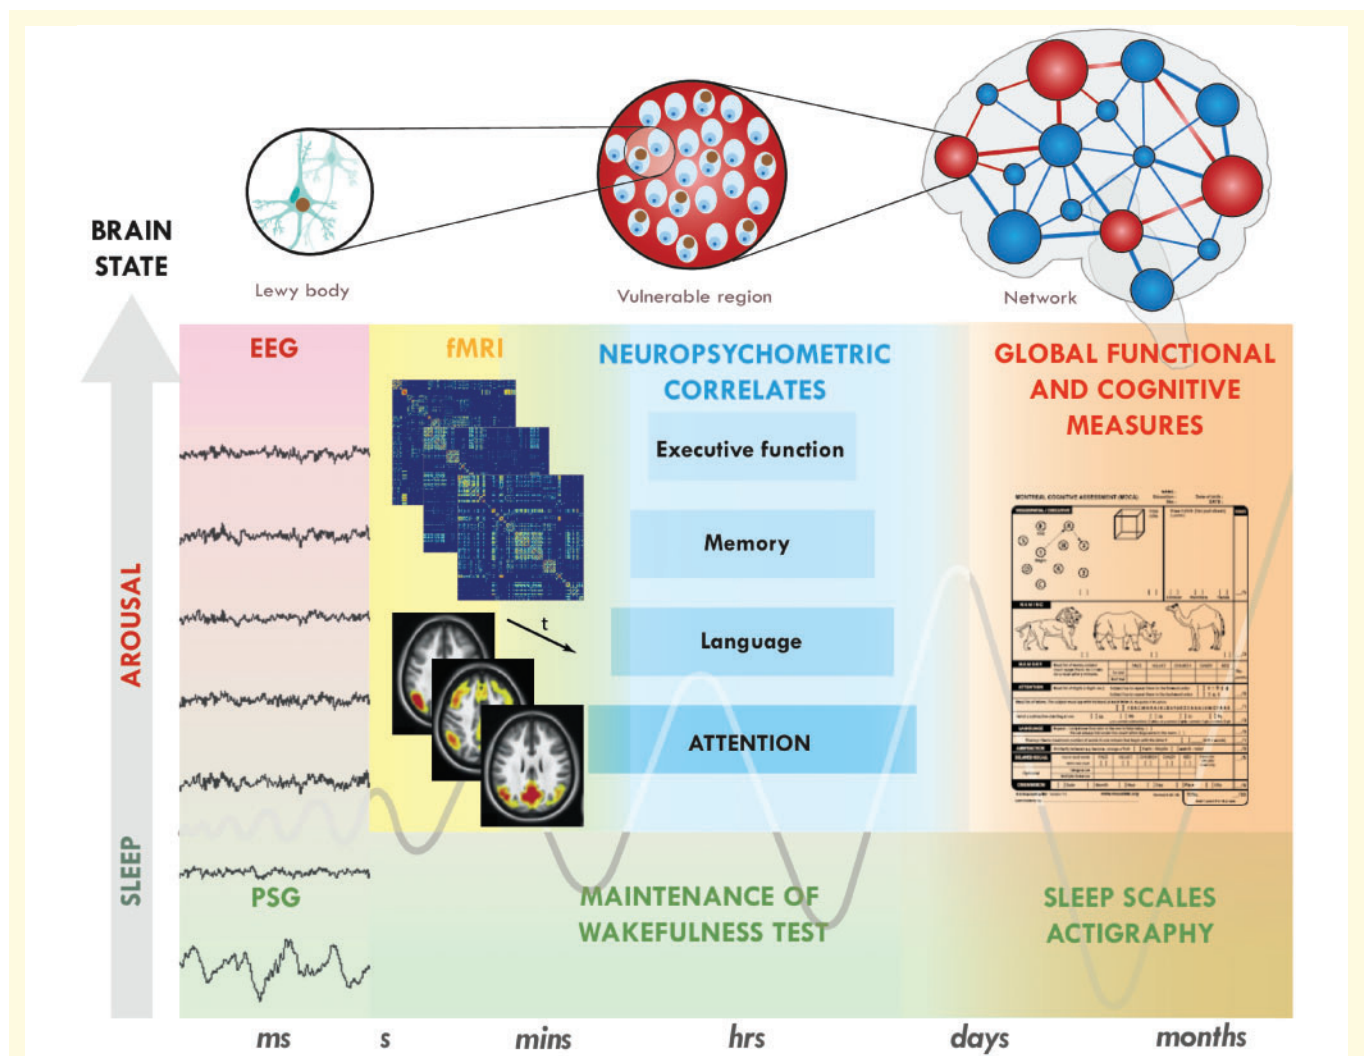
Overview of current methods for assessing and investigating cognitive fluctuations illuminates key heuristics that should be accounted for by pathophysiological models of fluctuations. Disrupted attentional processing is a sensitive neuropsychometric measure of fluctuations and seems to be affected early prior to other, more regionally localized cognitive domains. Fluctuations occur over multiple timescales, having been found to correlate with physiological variations detected in the order of seconds (e.g. EEG, functional MRI), through to changes in global cognitive and functional measures (e.g. Montreal Cognitive Assessment) that can be appreciated at timescales of months to even years. This heterogeneity limits the insights into mechanisms of fluctuations gained by the use any single tool that only reflect variations thin a specific range of time. Different phenotypes of fluctuations suggest dysfunction in a distributed neural system, emphasizing the need to consider the large-scale network-level influences of pathologically affected neural regions. Disrupted sleep and arousal, which are processes subserved by distributed neural systems, characterize fluctuations that are shown in the figure to occur along an axis of unconscious to conscious brain states. Fluctuations occur most frequently in and typify Lewy body dementias, thus the pathological substrate underlying this symptom must be especially influenced by Lewy body pathology.
